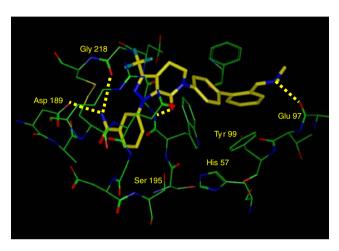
Factor Xa-bound X-ray structure of carboxamide 6d.
